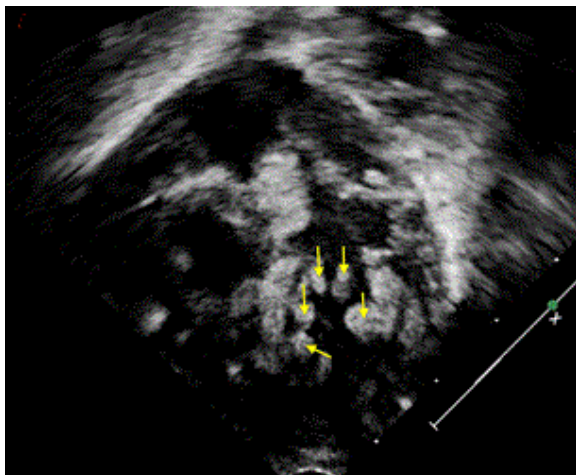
An echocardiogram showed multiple myocardial tubers.
